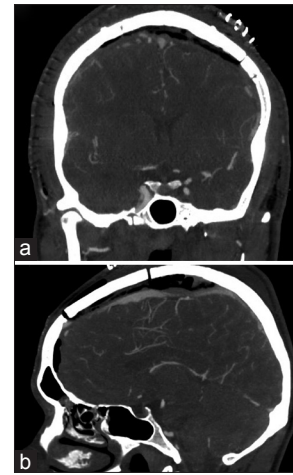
Postoperative CT angiogram head – (a) coronal cut at the level of the sphenoid sinus, (b) mid-sagittal cut, showing evacuation of epidural hematoma, resolution of the downward herniation, and patency of the superior sagittal sinus
